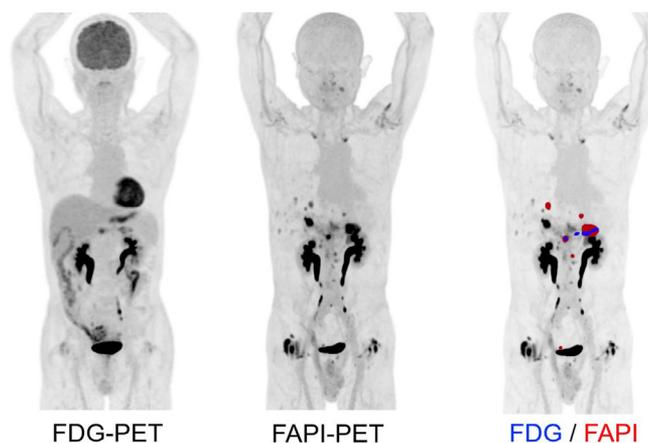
This intra-individual comparison of FAPI and FDG imaging in a patient with disseminated pancreatic cancer revealed superior diagnostic performance of FAPI imaging in terms of lesion-based detection rate (published with courtesy of Watabe et al.).
